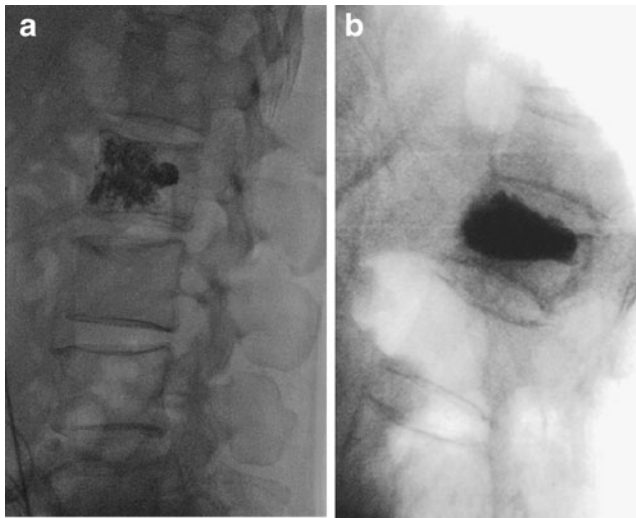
Lateral radiographs show two patterns of opacification after bone cement injection. a Trabecular pattern of opacification represented by opaque cement distributed throughout the trabecular space. b Cleft pattern of opacification represented by opaque cement filling a large intraosseous cavity
